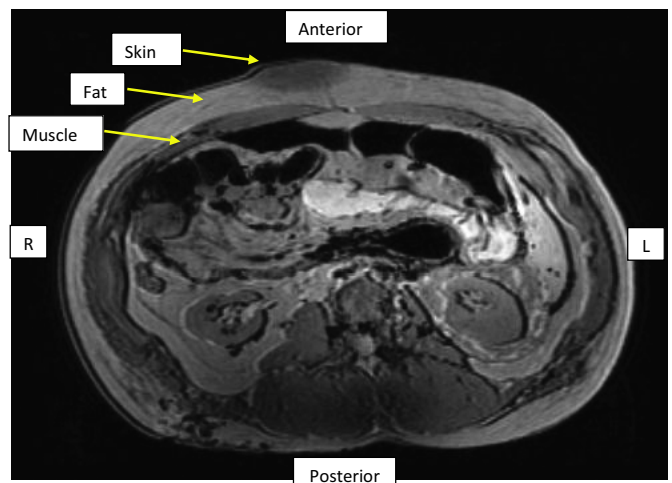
Representative posttest MR image of Torso 1 anterior impacts.
